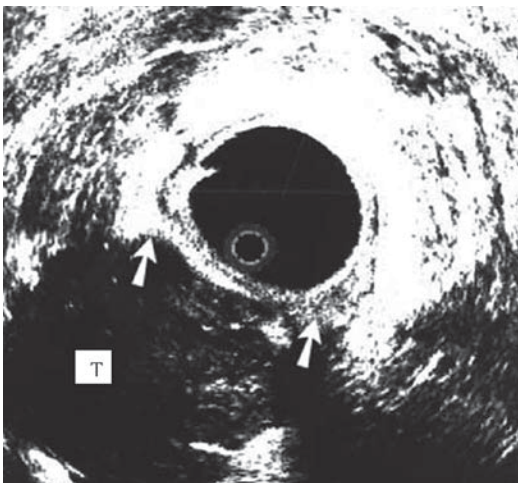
Endorectal ultrasound of a presacral tumor (Arrows;T).
